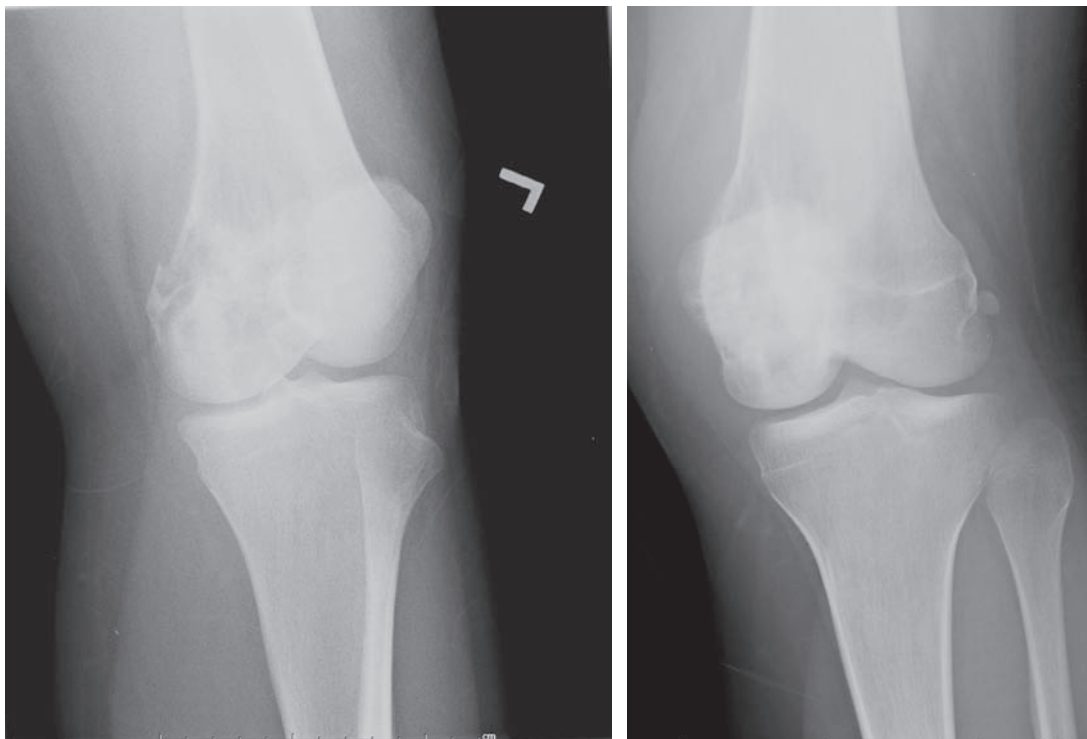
Two plain radiographs demonstrating osteosarcoma of the distal femur.
